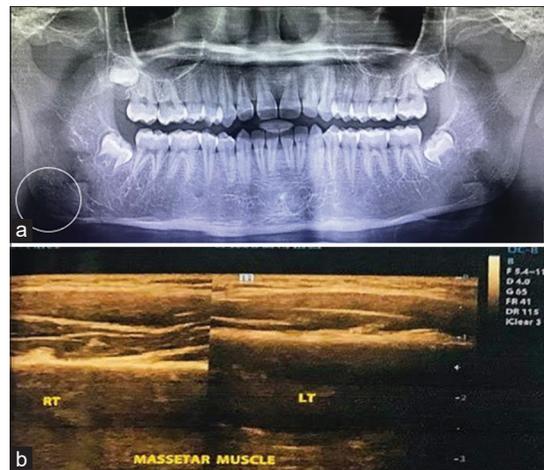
(a) Panoramic radiograph showing prominent right gonial notch (b) ultrasonography image showing hypertrophy of masseter muscle
